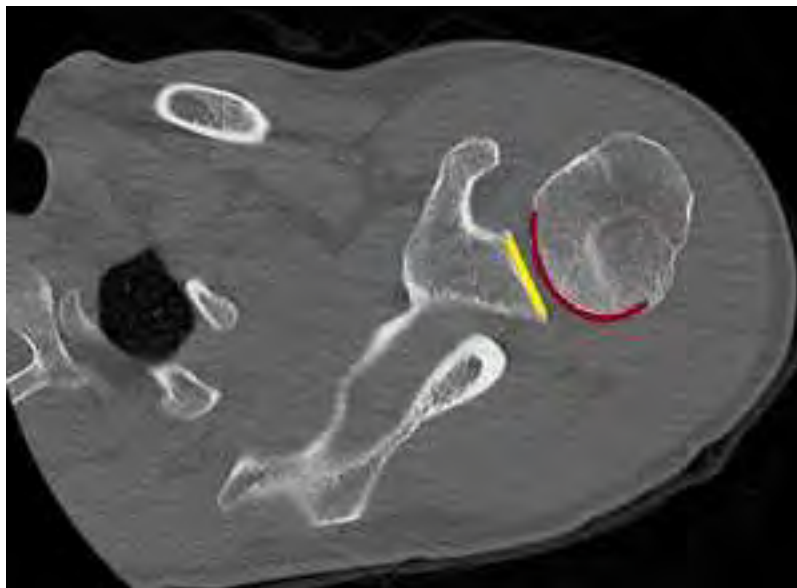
A CT scan of the shoulder, showing the mismatch between the size of the glenoid (yellow) and the size of the humeral head (red). (<https://radiopaedia.org/cases/normal-ct-shoulder-2>)
